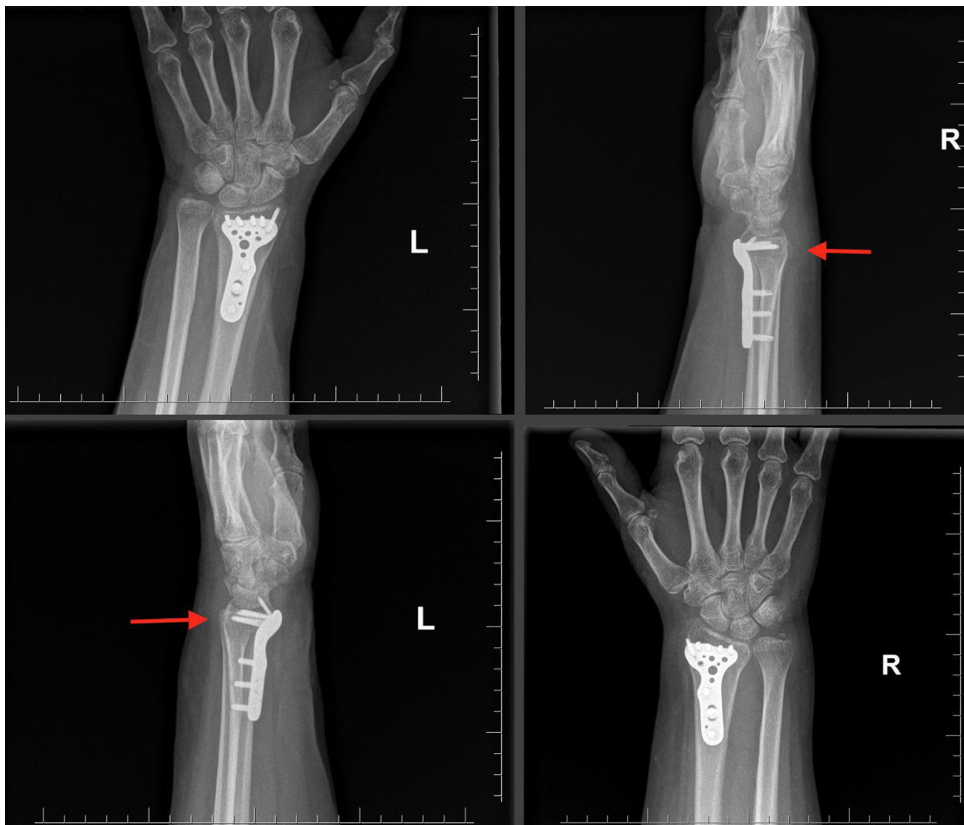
Postoperative radiographs of the left and right wrist of the patient, respectively. The red arrows indicate the mild dorsal cortical spikes on the dorsal cortices of both distal radii. However, the patient had no signs or symptoms related to these spikes since the EIP tendons were transferred through a subcutaneous tunnel.
